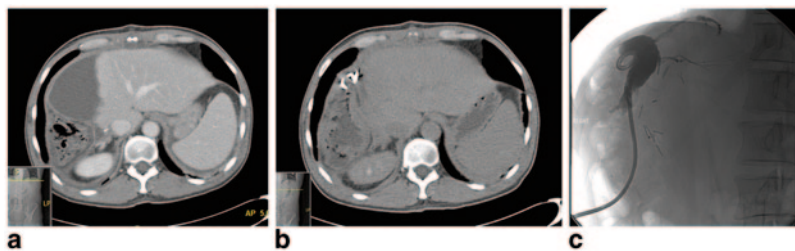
a CT abdomen demonstrates perihepatic fluid collection after right hepatectomy. b CT-guided percutaneous drain placement of biloma. c Sinogram demonstrates opacification of a cavity communicating with the biliary tree
